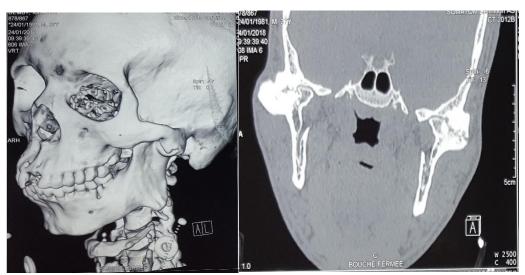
CT scans of a patient showing a stage III topazian
